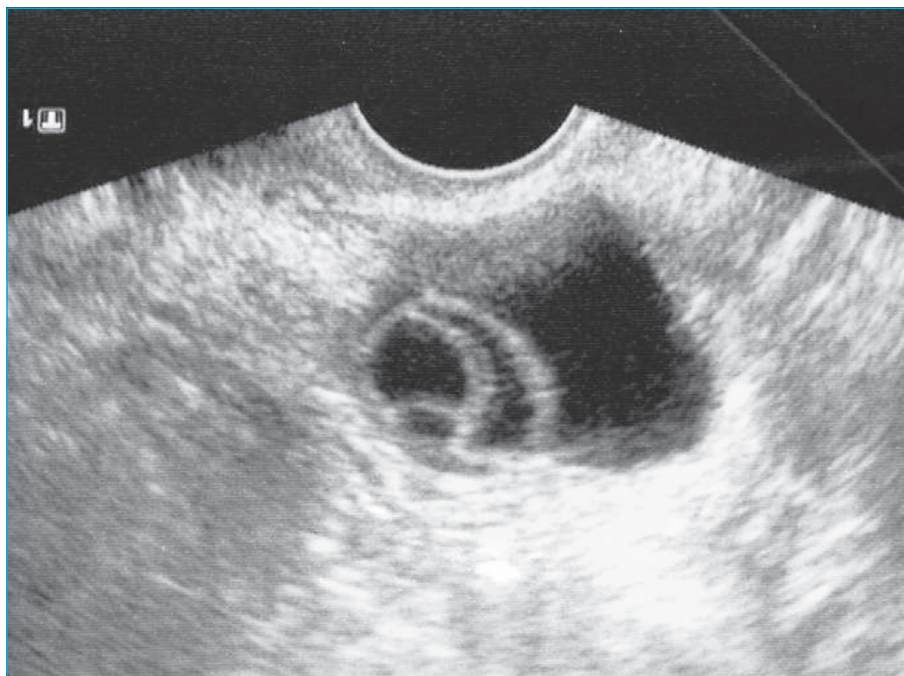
Ultrasonography of the broad ligament during the fifth ovarian stimulation attempt. Four follicles (26, 18, 15 and 9 mm in size) were observed on day 13.
